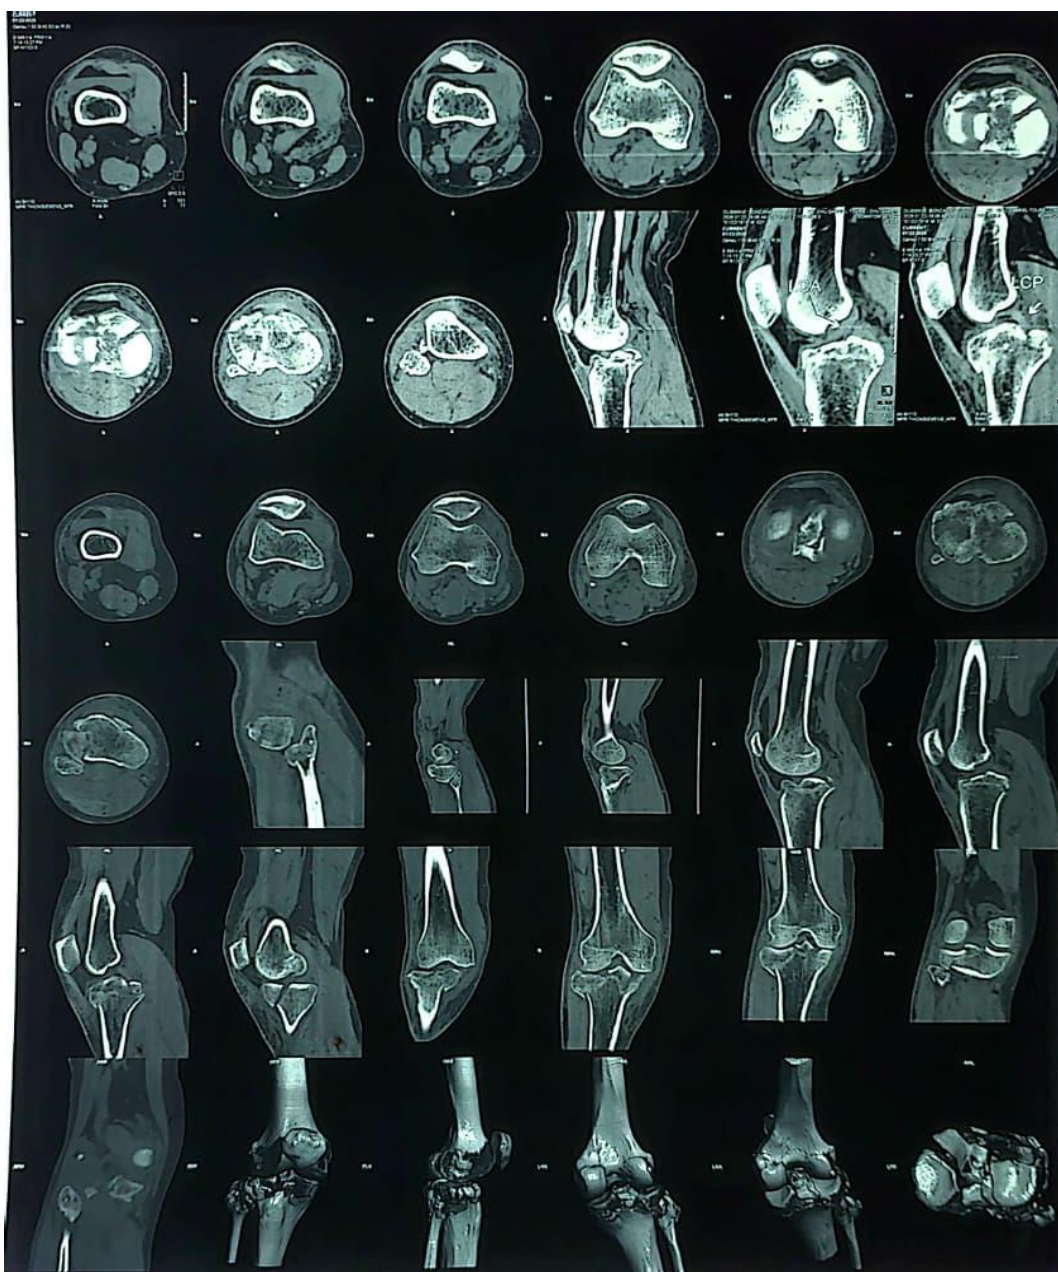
CT scan images showing a complex fracture of the tibial plateau
